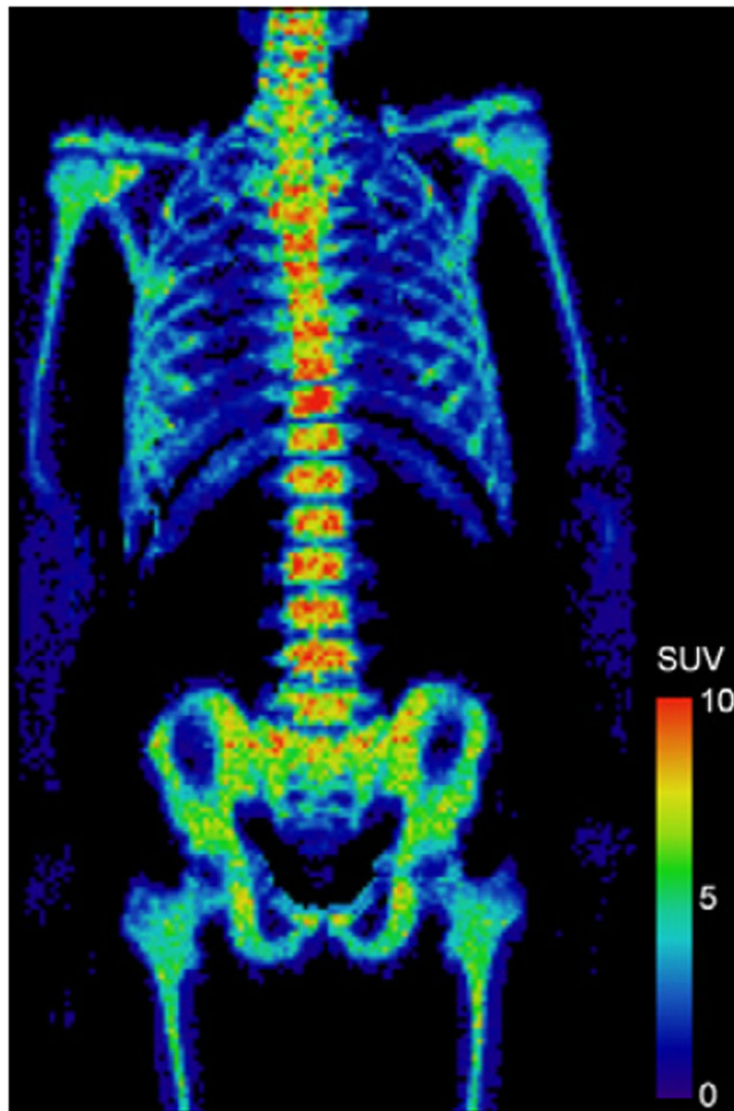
Comparison of CR and RD patients, pre- and post-treatment. Pre-treatment: FLT PET image of bone marrow of RD patient (D) exhibited markedly greater uptake than CR patient (A). Post-treatment: FLT PET images (B and E) and SUV distributions (C and F) revealed very low uptake for CR patient but substantial uptake for RD patient.
